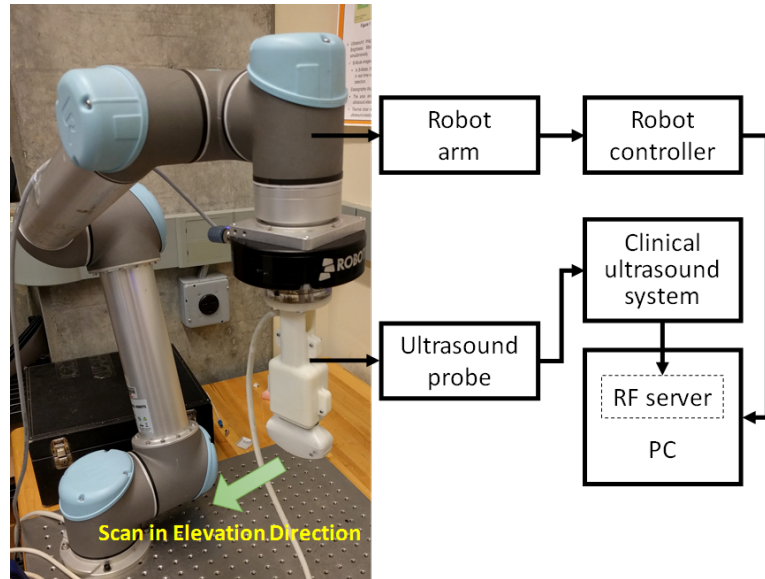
The experiment setup. A pure translational motion in the elevation direction is assigned. The ultrasound data at each tracking timing has been recorded through a clinical ultrasound machine.
